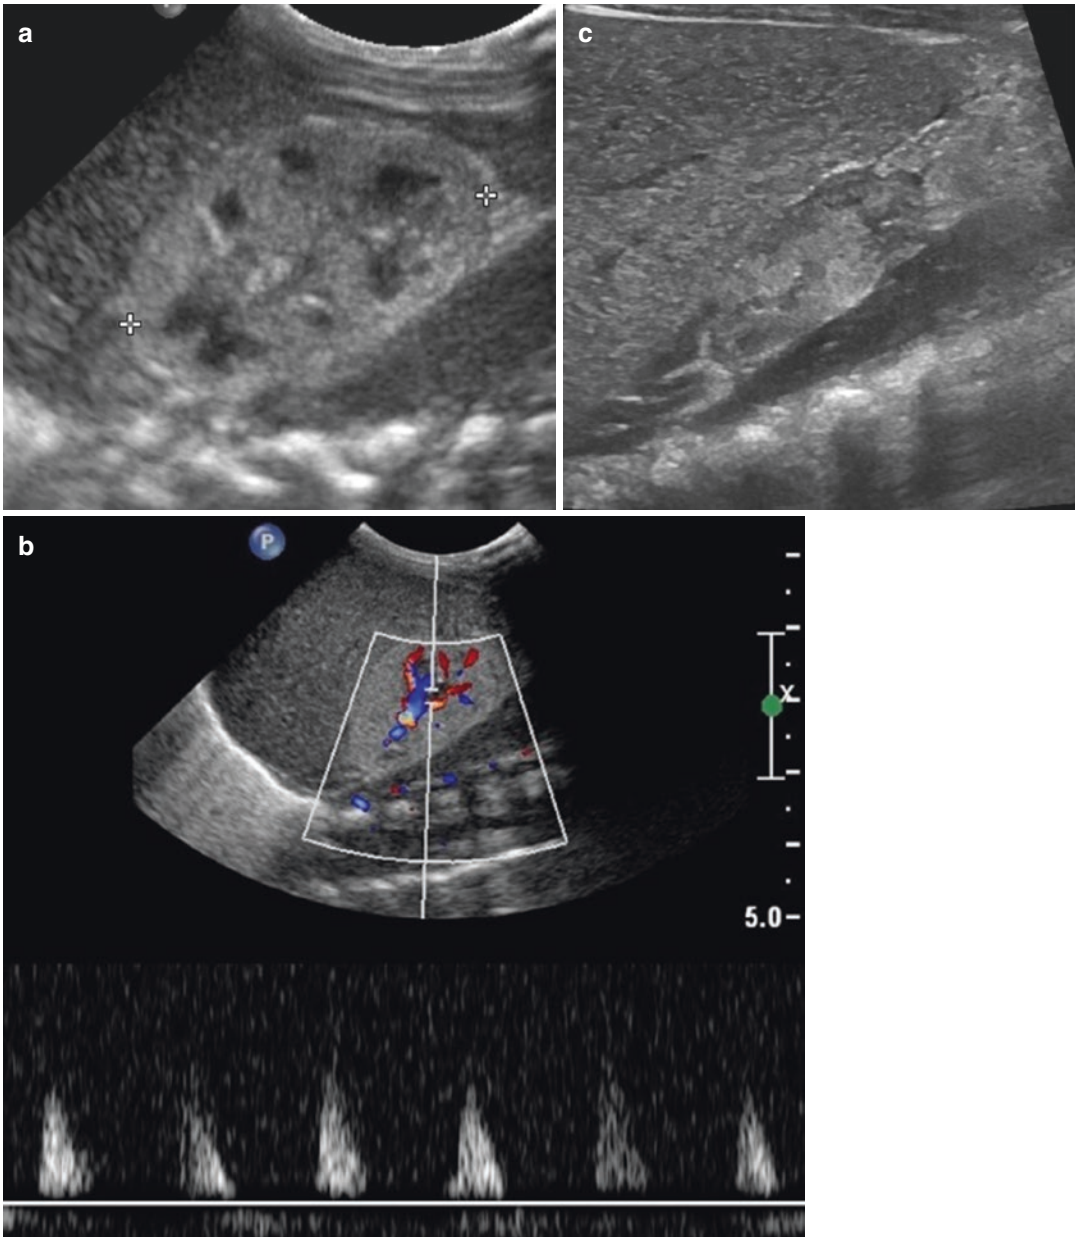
Global renal ischemia—Ultrasound. (a) Sagittal scan of the right kidney (between the crosses). The renal cortex appears hyperechoic. (b) Duplex Doppler
